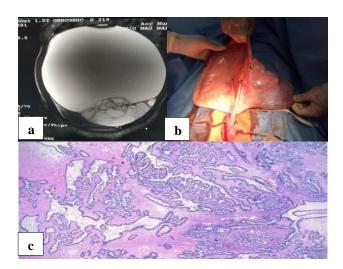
Patient 2 – borderline ovarian tumour (a) CE MRI- large cystic ovarian mass, (b) intraoperative image- large right ovarian mass with normal left adnexa, and (c) HPE-borderline ovarian tumour right side.
